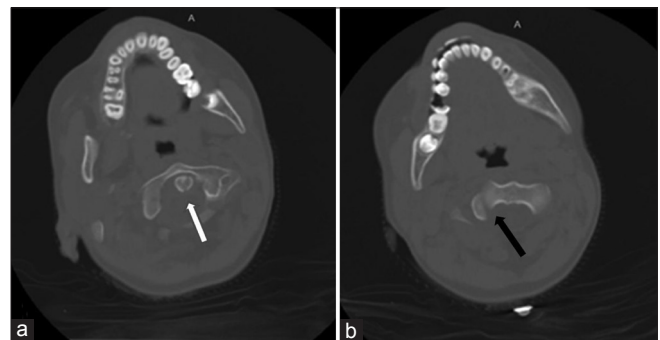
(a) Axial upper cervical CT determined suspicious fracture line in odontoid process (white arrow) with (b) Type I AARS (black arrow)
